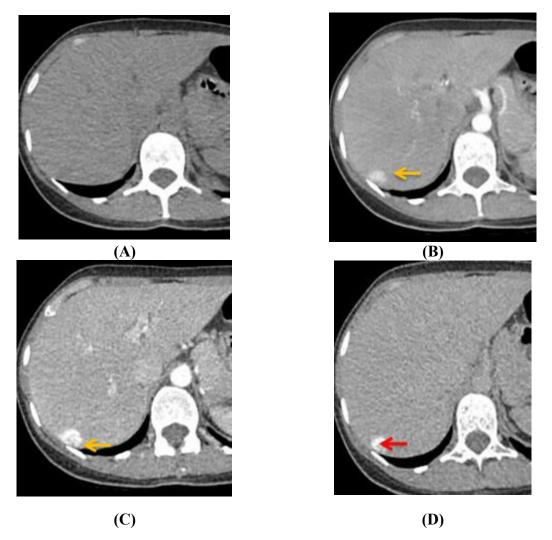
Axial CT images obtained prior to contrast administration (A), after contrast administration at arterial phase (B), porto-venous phase (C) and delayed phase (D) revealed a 19-mm right hepatic lobe focal lesion at segment VII revealing hyperenhancement at arterial and porto-venous phases (yellow arrows) and no washout at delayed phases (red arrow)
